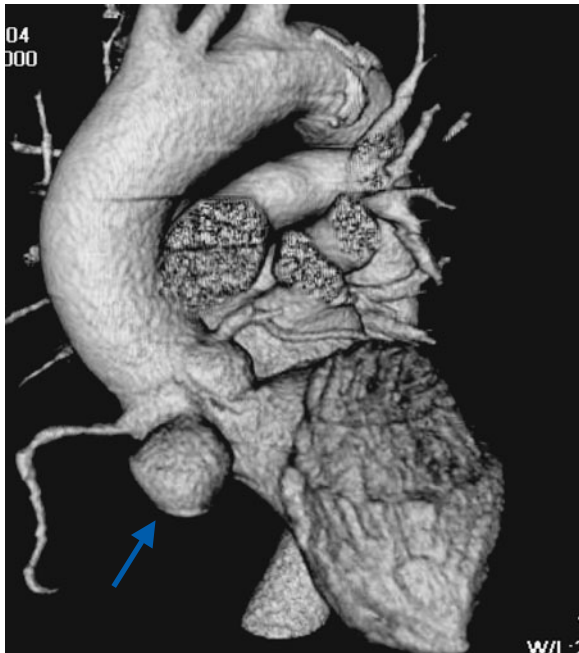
Cardiac CT provides optimal visualization of complex aortic root pathology. Prior echocardiogram suggested the entire aortic root to be aneurysmal at more than 4.5 cm in this patient. Three-dimensional volume-rendered image from cardiac CT demonstrates a 2.6-cm sinus of Valsalva aneurysm arising off the right coronary sinus (arrow). The remainder of the aortic root is normal. Using saline flush and thresholding techniques for image display, high-resolution unobstructed visualization of such lesions is possible.
